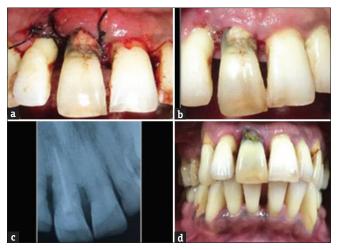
(a) Immediate postoperative frontal view, (b) 1-month postoperative frontal view, (c) 4-month postoperative radiographic view showing obturated canal, and (d) 4-month postoperative frontal view
